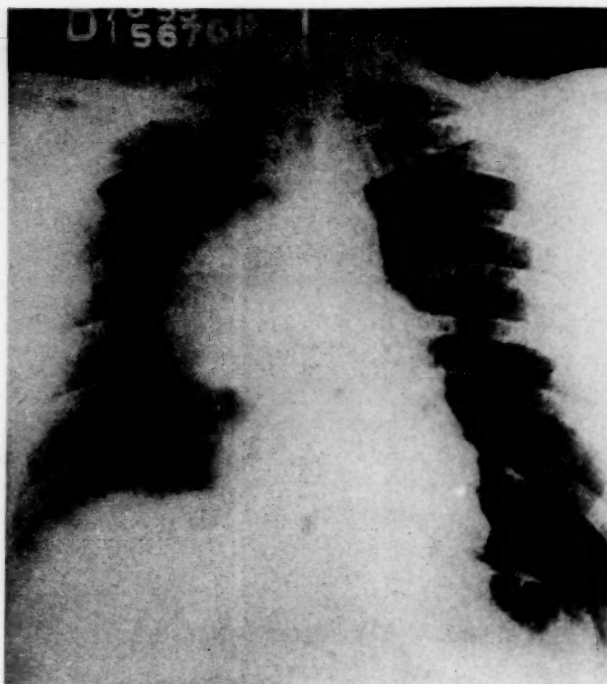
X-ray taken before radiation therapy, Case III.
